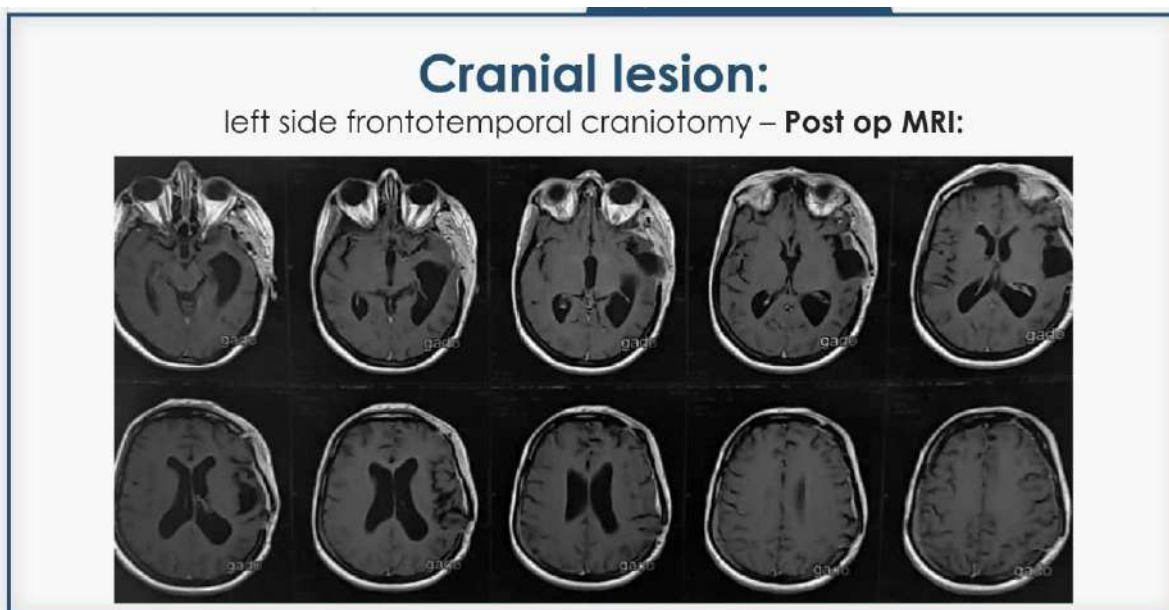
postoperative MRI Brain with Gad
